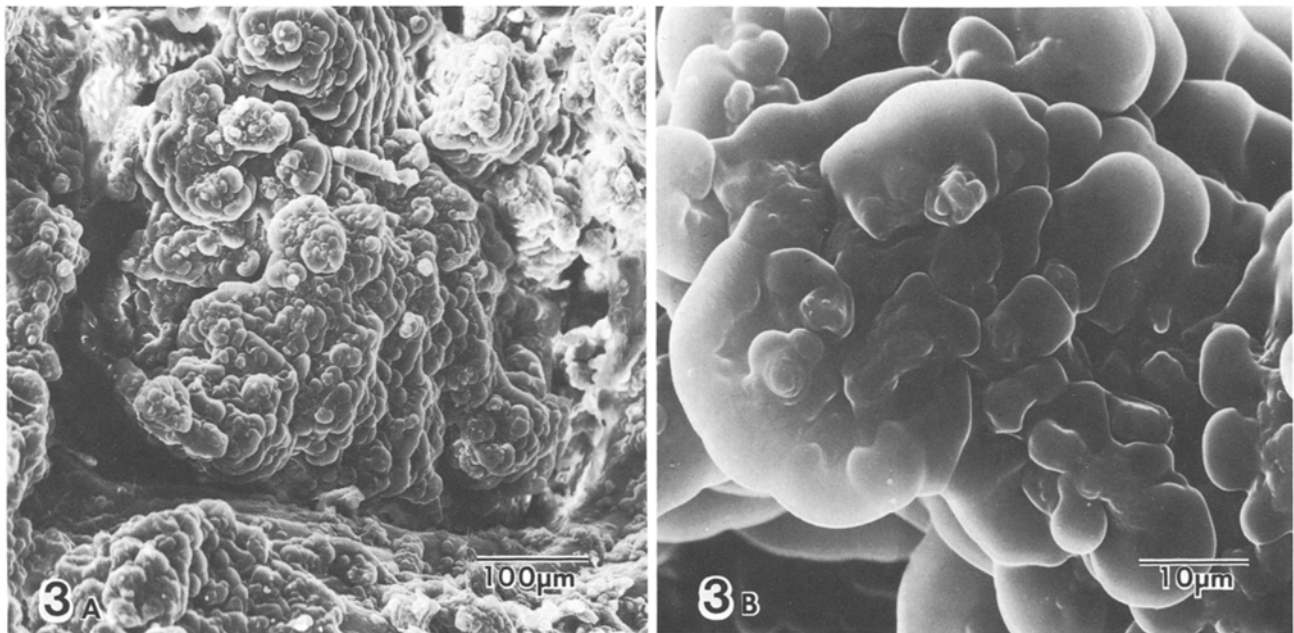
Peculiar leaf shaped deposits on the surface of a brushite stone (*not shown*). X-ray analysis of the leaves yielded only silicon
